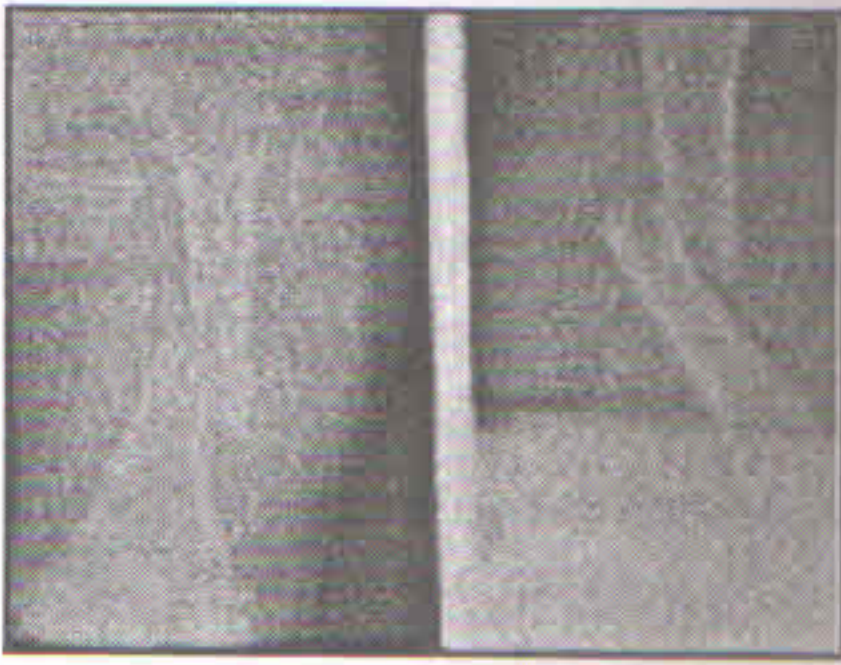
Pre-operative x-ray showing fracture shaft of femur
